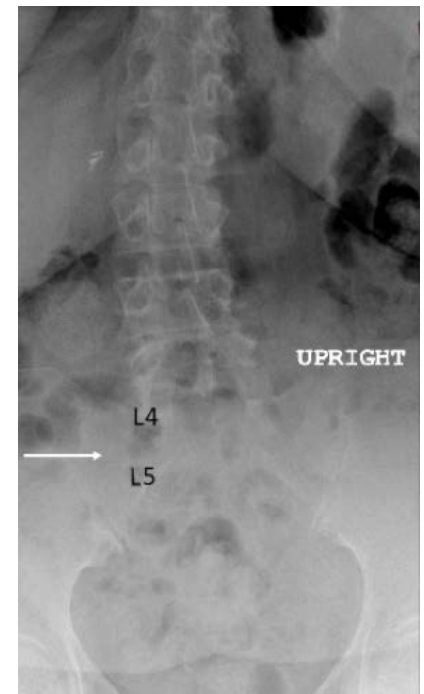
Pre-operative anteroposterior lumbar spine x-ray at L4-5. The arrow indicates narrowing of the disc space between L4 and L5.
